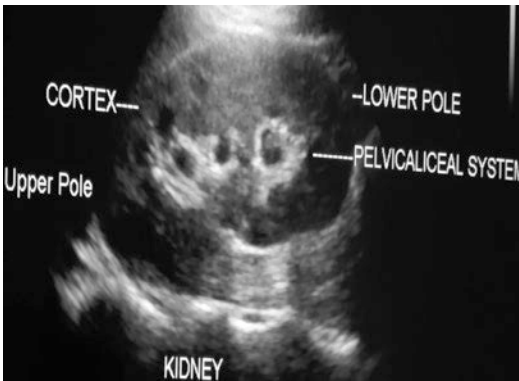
Normal kidney as visualised in 2D sonography
